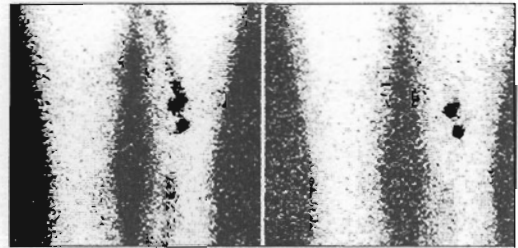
Detection of a popliteal sentinel lymph node: static lymphoscintigraphic images at 30 and 120 minutes.
